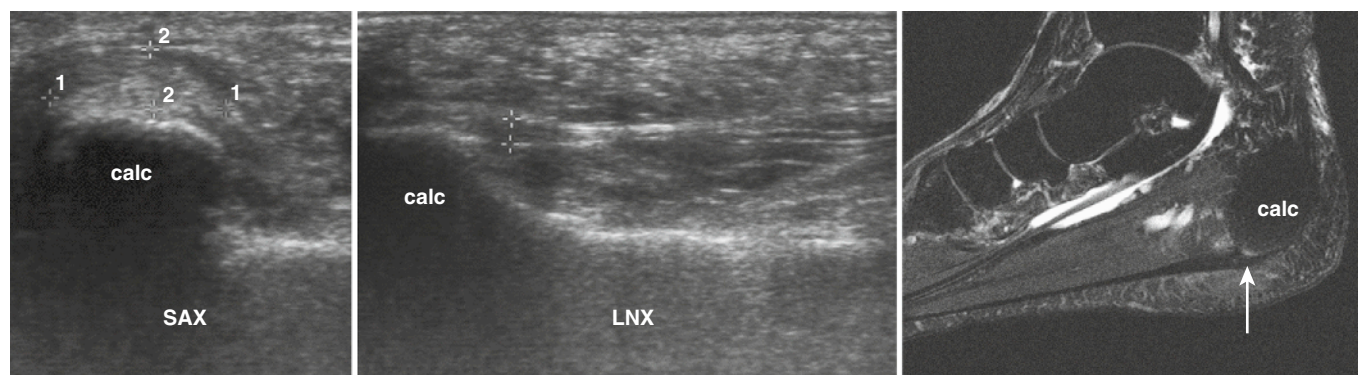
Posterior tibialis longitudinal split (*cursors*) with enlarged origin at the calcaneus (calc). Note the high signal intensity on MRI.
